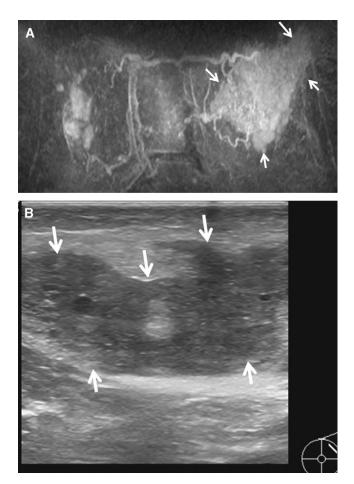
A 37-year-old lactating woman who presented with a palpable mass in left axillary tail. Ultrasound (US) was initially called normal. (A) Coronal 3-dimensional maximum intensity projection image of her breast magnetic resonance imaging, showing asymmetric enhancement in the entire left upper outer quadrant (arrows), which corresponded to the palpable mass. (B) Second-look US, demonstrating a large hypoechoic area (arrows) that is distinct from the normal hyperechoic glandular tissue. US-guided biopsy of the abnormal area yielded the diagnosis of high-grade ductal carcinoma in situ, which was confirmed at mastectomy.
